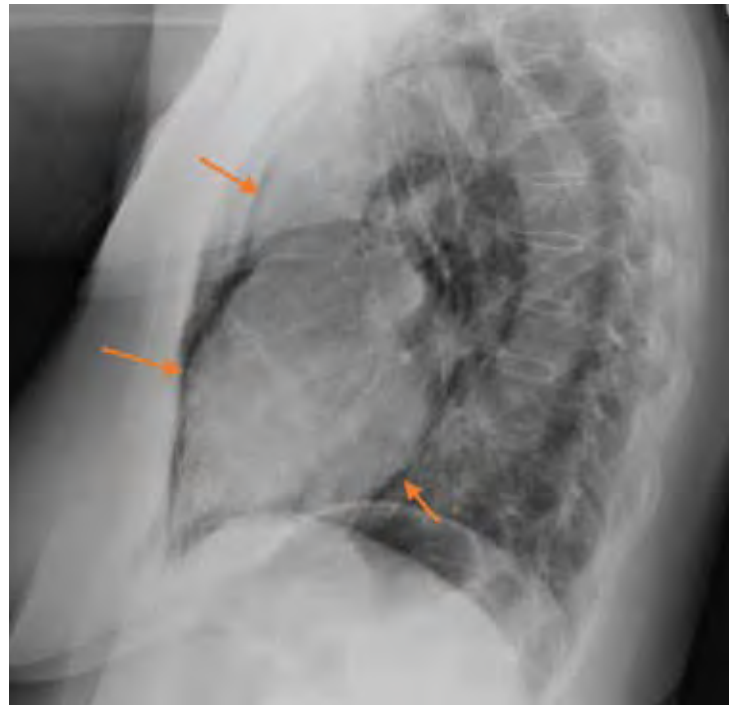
CHEST X-RAY SHOWS THE AIR OUTLINING THE MEDIASTINAL CONTOURS, INCLUDING CONTOURS OF THE MEDIASTINAL VESSELS (SUPERIOR VENA CAVA, AORTA AND PULMONARY ARTERY) AND HEART (ORANGE ARROWS).
